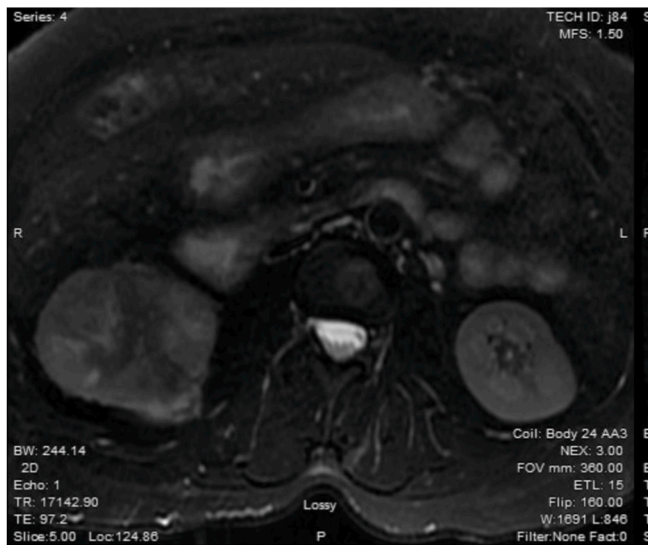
Abdominal MRI: MRI Abdomen without contrast showing a solid enhancing right lower pole mass measuring 7.8 x 7.0 x 5.6 cm.
